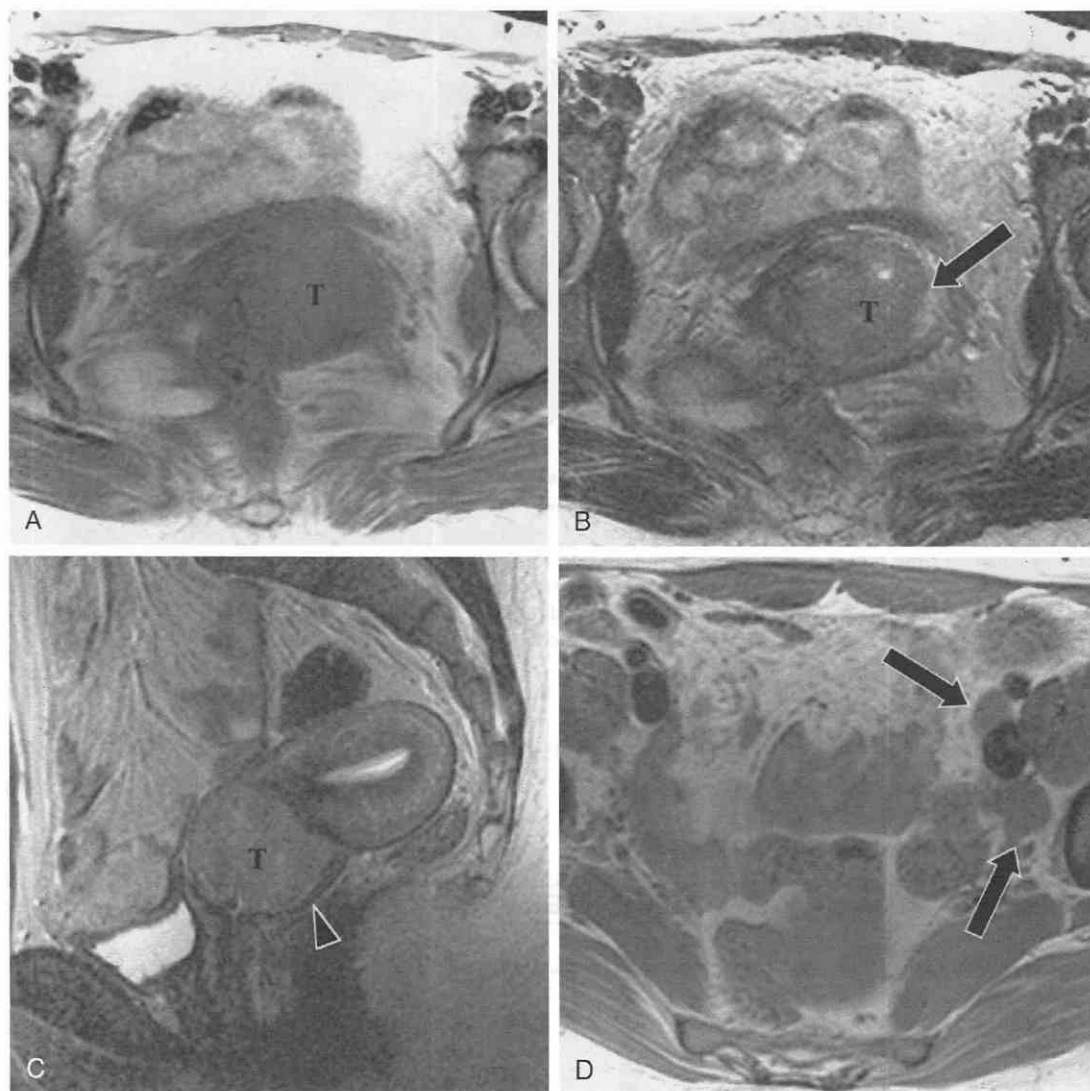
Cervical carcinoma, stage IIB. *A*, T1-weighted image shows cervical enlargement (T). No differentiation of tumor and cervical stroma is seen. *B*, Axial T2-weighted, fast spin-echo image shows high-signal-intensity tumor (T) arising from the left cervical lip and growing into the left parametrium (arrow). *C*, Sagittal T2-weighted, fast spin-echo image demonstrates the tumor (T) without invasion superiorly into the uterine corpus. The low-signal intensity of the posterior vaginal fornix (arrowhead) is identified. *D*, T1-weighted spin-echo axial image shows metastases to the left external iliac lymph nodes (arrows).
